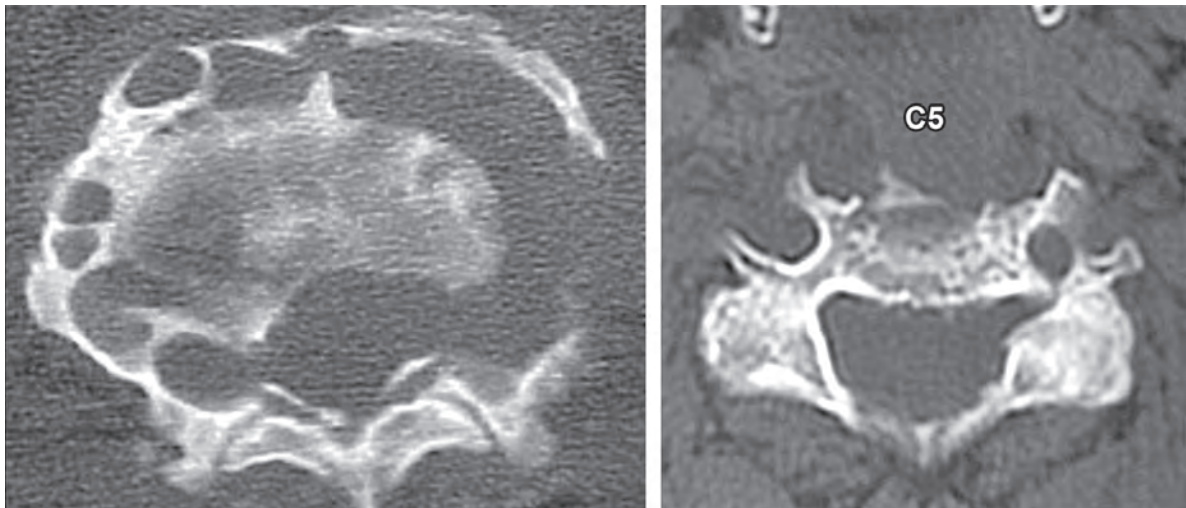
CT axial views of a patient with cervical caries showing significant bony destruction
